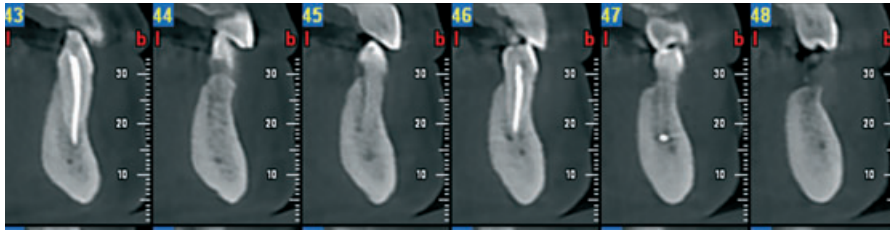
CBCT examination (coronal slices/cuts) of tooth 34 revealing that the filling material was not in contact with the mandibular canal.
